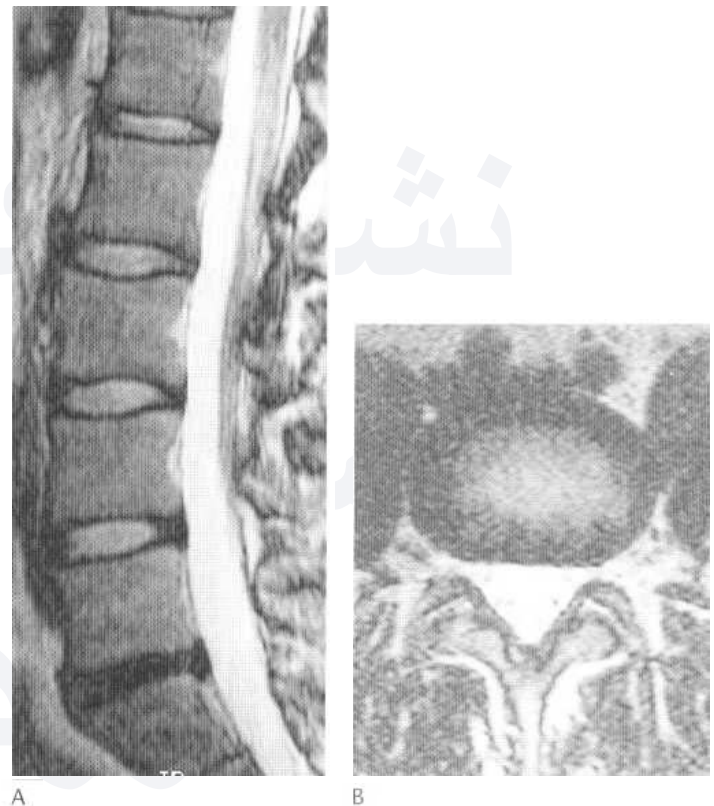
Normal and degenerative lumbar intervertebral discs. Sagittal (A) and axial (B) MRI, T₂-weighted contrast. Normal discs are surrounded by low signal from the annulus fibrosis and partly divided horizontally by a low-signal band, not present in children's discs.
